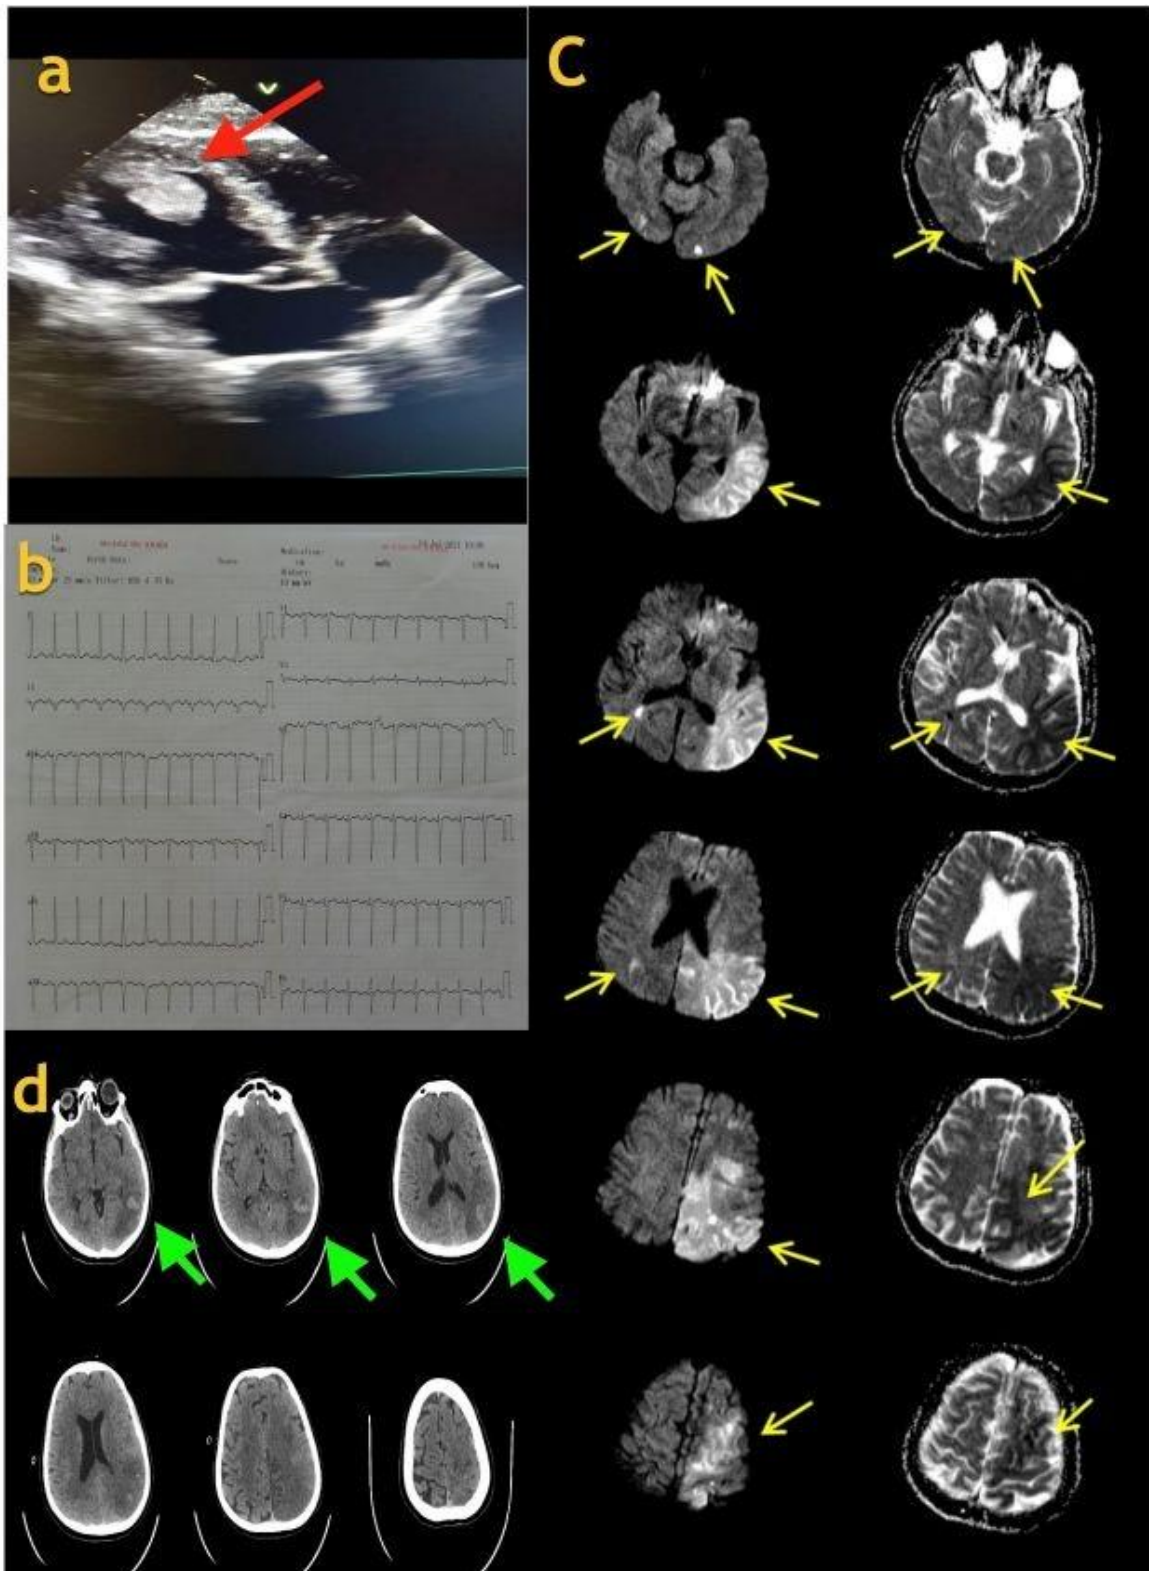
Apical thrombus in the left ventricle shown in red arrow (a). Poor R wave progression in anterior derivations(b). Diffusion restriction in the region supplied by middle cerebral artery on cranial magnetic resonance imaging consistent with wide ischemic infarct(c). Acute-subacute hematoma in parietooccipital region on cranial tomography
